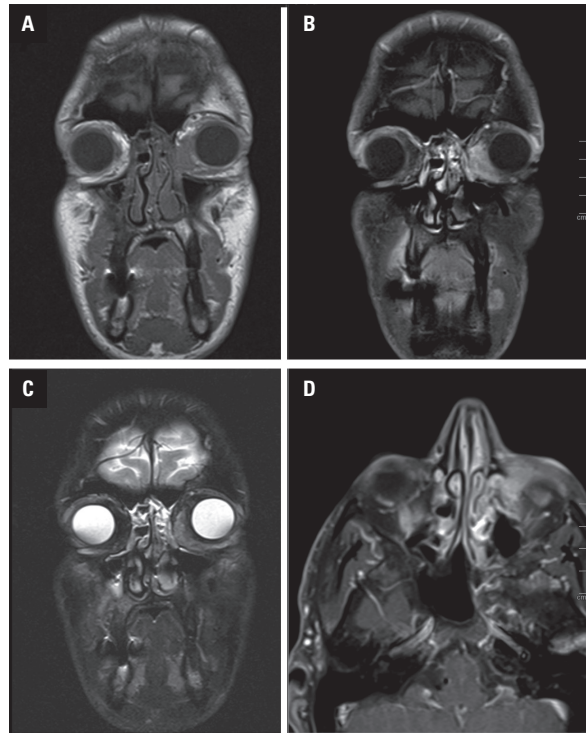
A. Orbit MRI coronal view T1; B. T1 post contrast fat sat; C. Short TI inversion recovery (STIR); D. Axial T1 post contrast fat sat. A lobulated mass at left medial canthus invading the lacrimal sac and the medial orbital rim. The mass is inseparable from anterior eye globe, medial rectus and inferior oblique muscles. The mass is invading the lacrimal sac and the upper part of the left nasolacrimal duct
